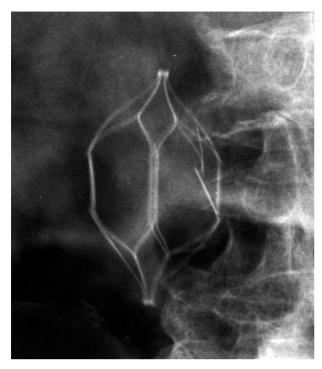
X-ray showing one of three fractured Trapease filters.
